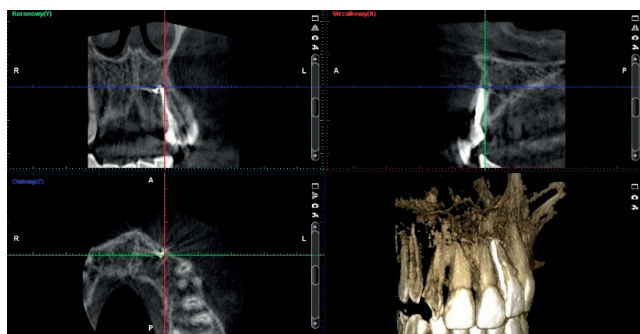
Cone beam computed tomography scans 1 year after root canal treatment. The structure of bones was rebuilt. The pushed sealer did not disturb the healing process
